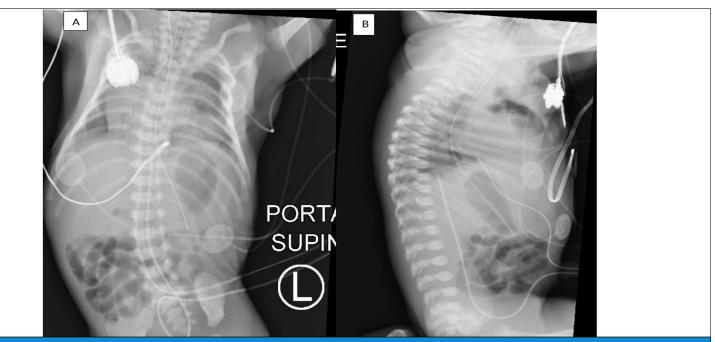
Chest and abdominal X-rays Anteroposterior and lateral views to access umbilical line position.: A: Anteroposterior view showing UVC at T8 vertebral level, enlarged cardiac shilloutte, orogastric tube in the distal stomach and an endotracheal tube at T2-T3 vertebral level. B: Lateral X-ray showing UVC tip at the level of the diaphgram.
